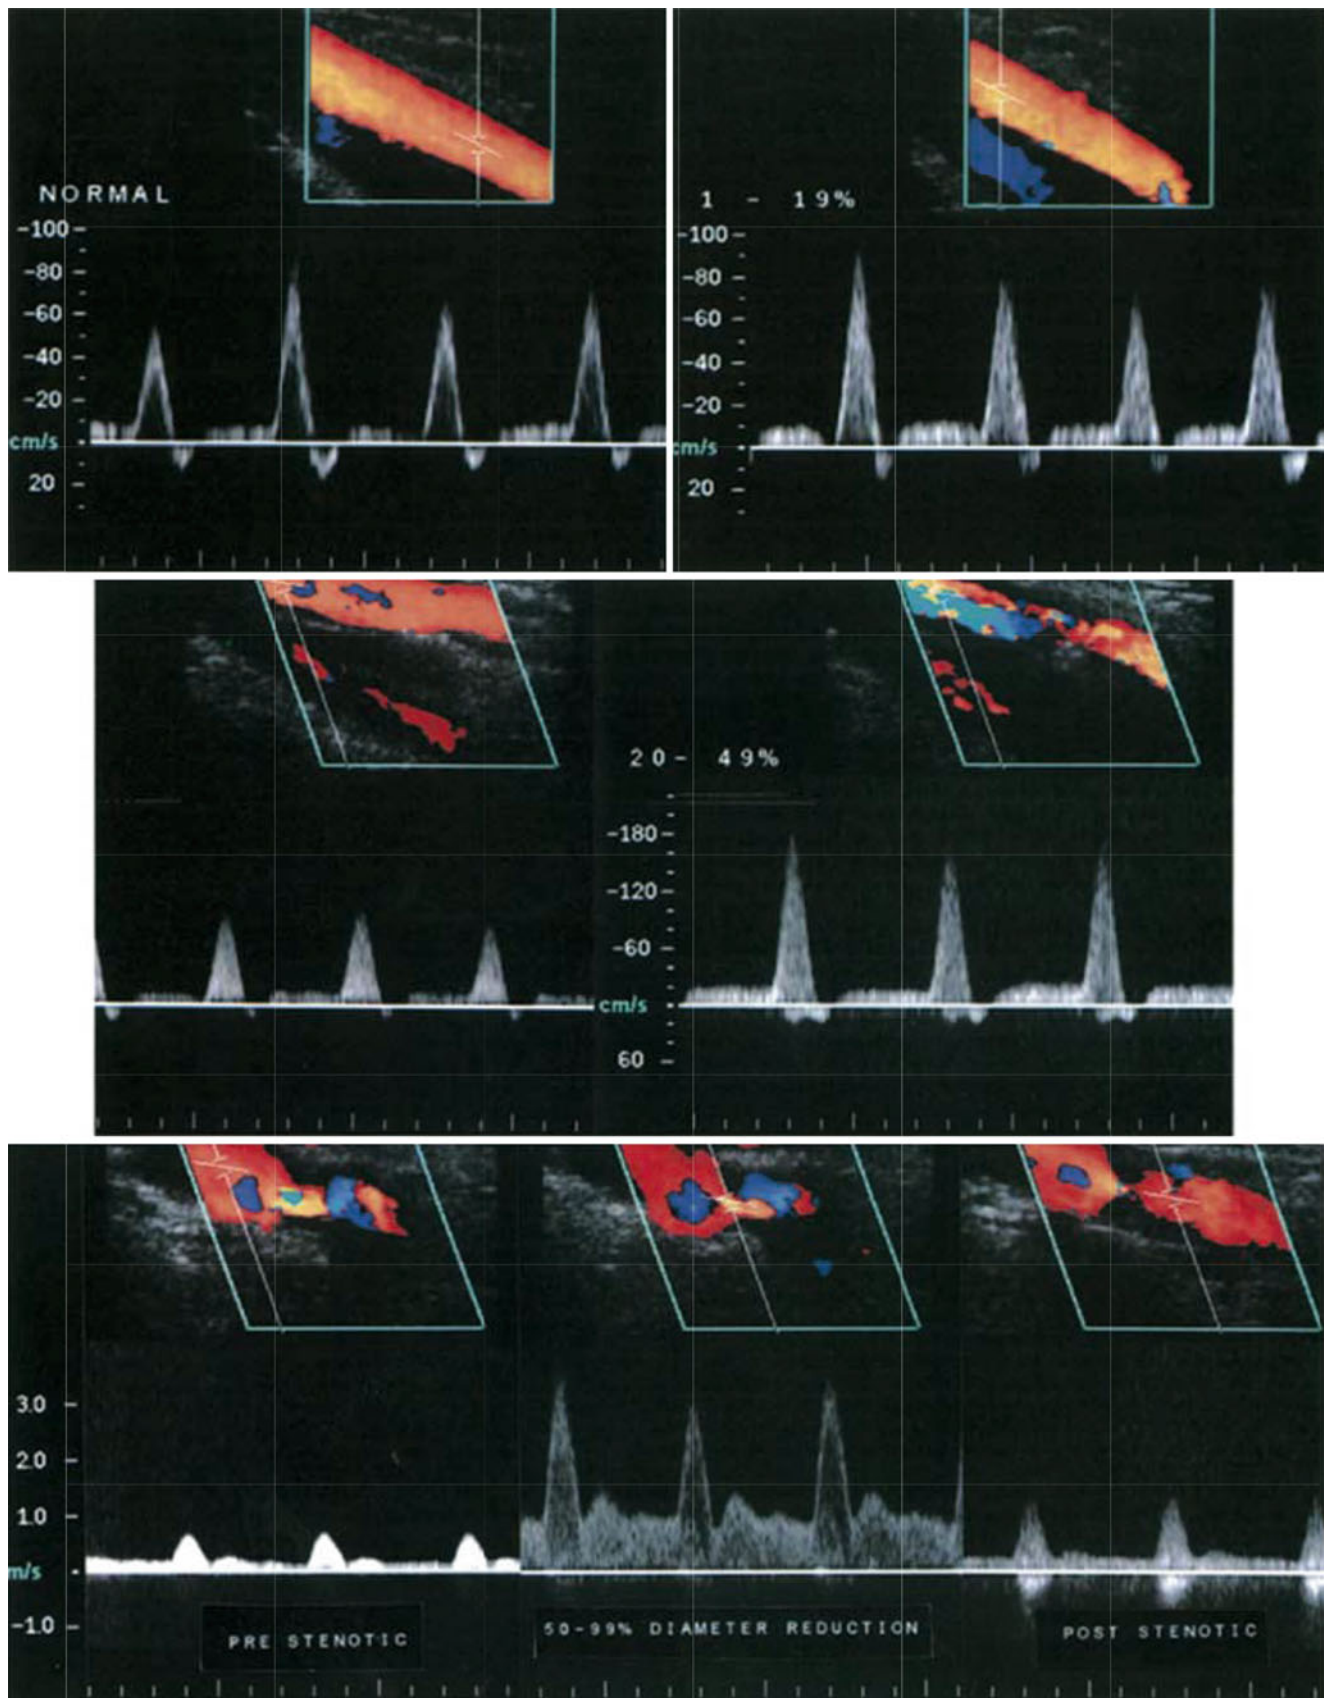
Arterial velocity waveforms. Typical arterial doppler velocity waveforms. The normal waveform is triphasic. As the degree of stenosis increases, the waveform becomes dampened and monophasic and the peak velocities increase. Clinically significant lesions (greater than
